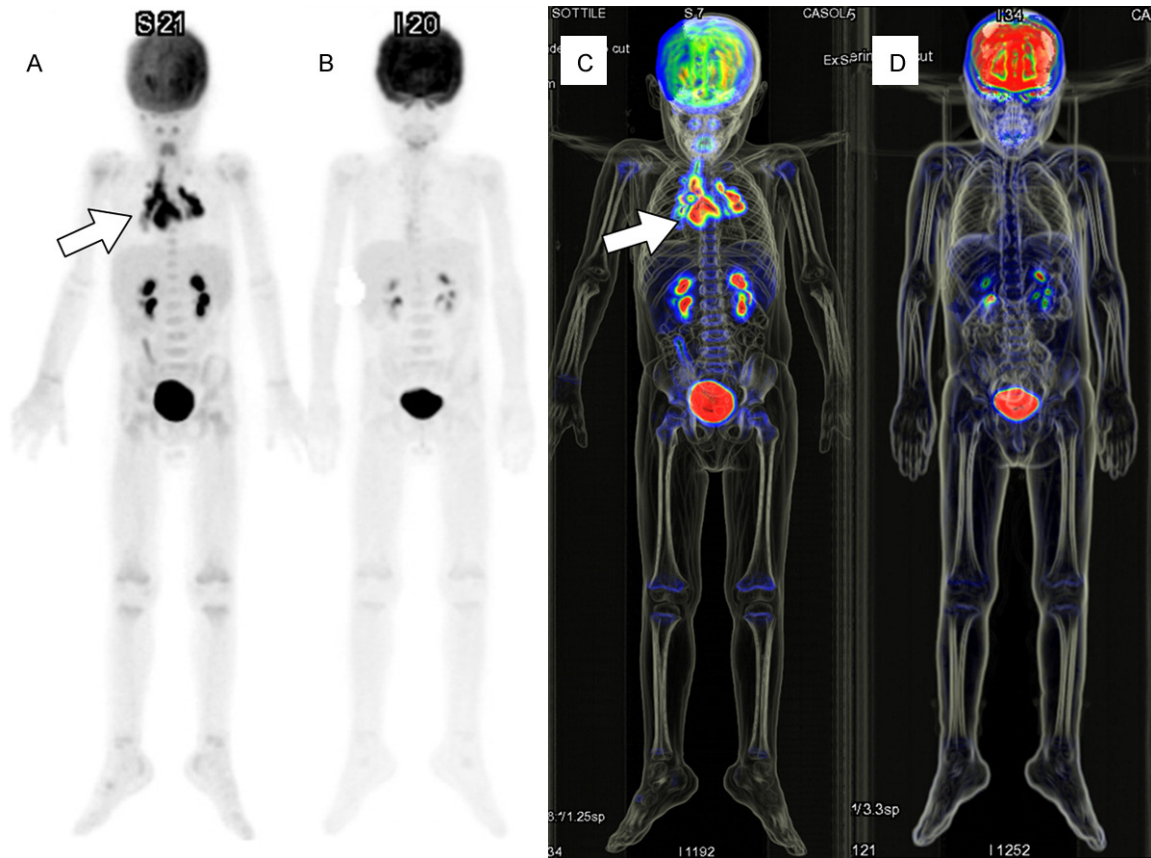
Therapy monitoring in 6-year-old patient with Non-Hodgkin Lymphoma. FDG PET maximum intensity projection image (A) and Volume Rendering (C) show high FDG uptake in mediastinal lymph nodes (arrowheads); no more activity in the post-therapy study (B and D).
